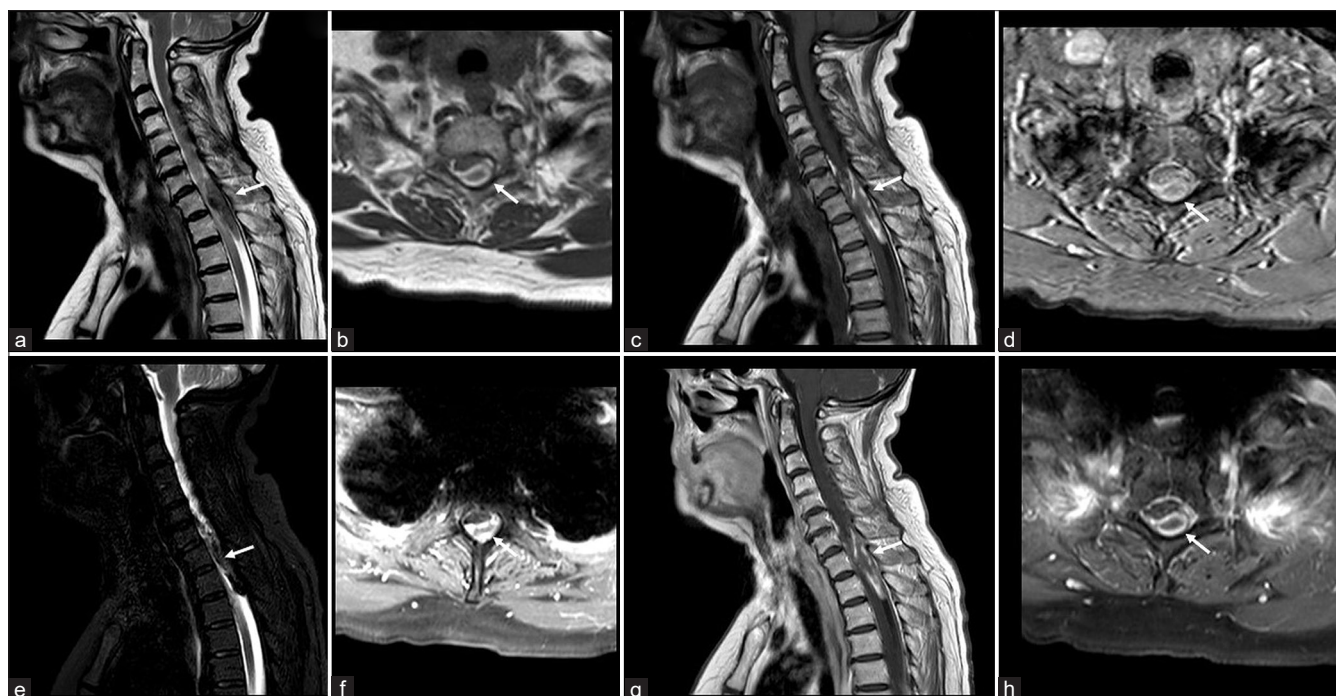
Initial MRI of the cervical and proximal thoracic spine. Sagittal T2WI (a), axial T2WI (b), sagittal T1WI (c), axial T1WI (d), sagittal STIR (e), and axial STIR (f) images demonstrate an inhomogeneous intradural extramedullary collection in the posterior spinal canal at levels C VII to Th III, compressing the spinal cord. There is also some T1-hyperintense material in the anterior subdural space. Postcontrast sagittal T1wi (g) and axial FS T1WI (h) do not demonstrate any contrast enhancement. The hematoma location is marked with white arrow in all images.
